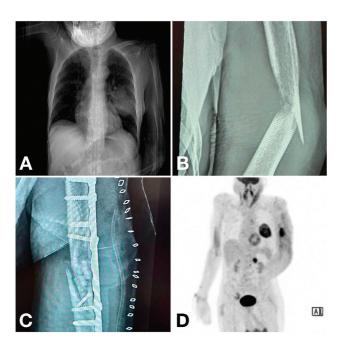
(A) X-ray chest: lesion in the mid-zone of the left lung. (B) X-ray: Fracture of the left humerus following a trivial trauma. (C) Postoperative Xray. (D) PET-CTwith fluorodeoxyglucose (FDG): avid lesion in the left lung, mediastinal lymph nodes, left adrenal gland, and left humerus.
